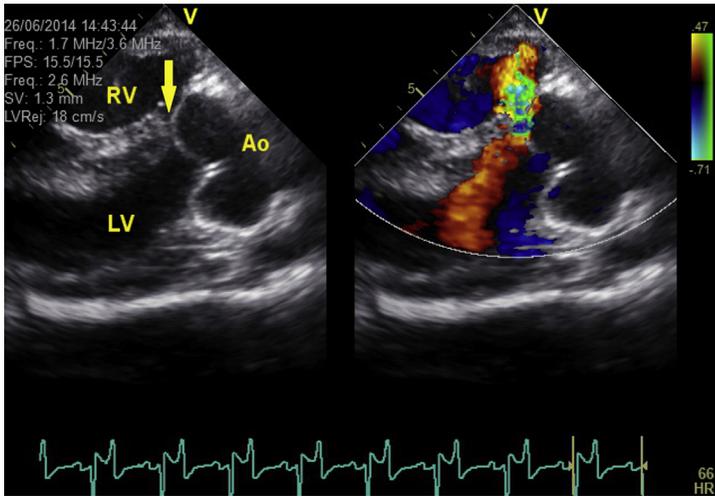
2D B-mode (*left*) and simultaneous color Doppler recording (*right*) of the right parasternal long-axis, modified LVOT view. A restrictive perimembranous VSD (*arrow*) is present. Color flow mapping indicates turbulent shunt flow (color coded in *green*) through the defect during diastole.
